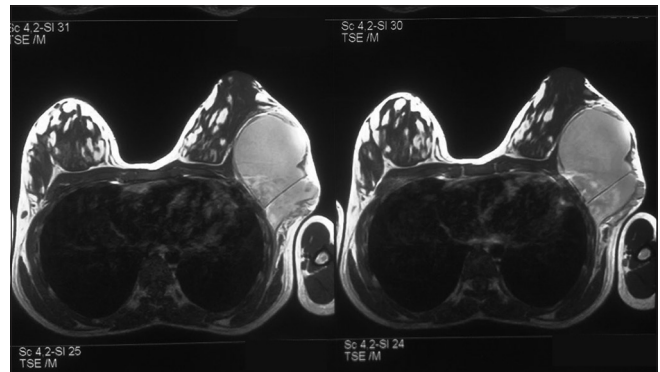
Magnetic resonance imaging of the breast
